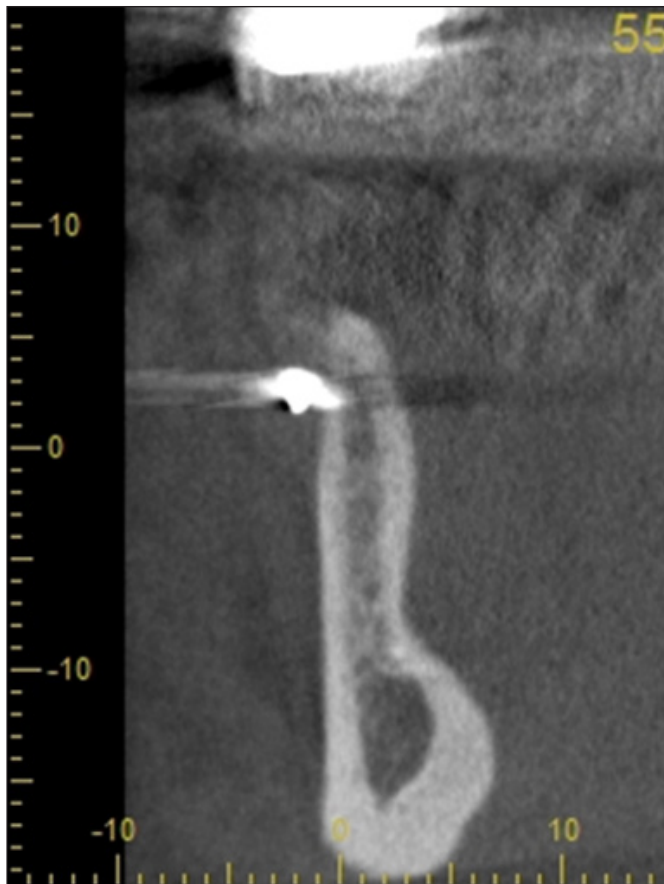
Preoperative CBCT image
